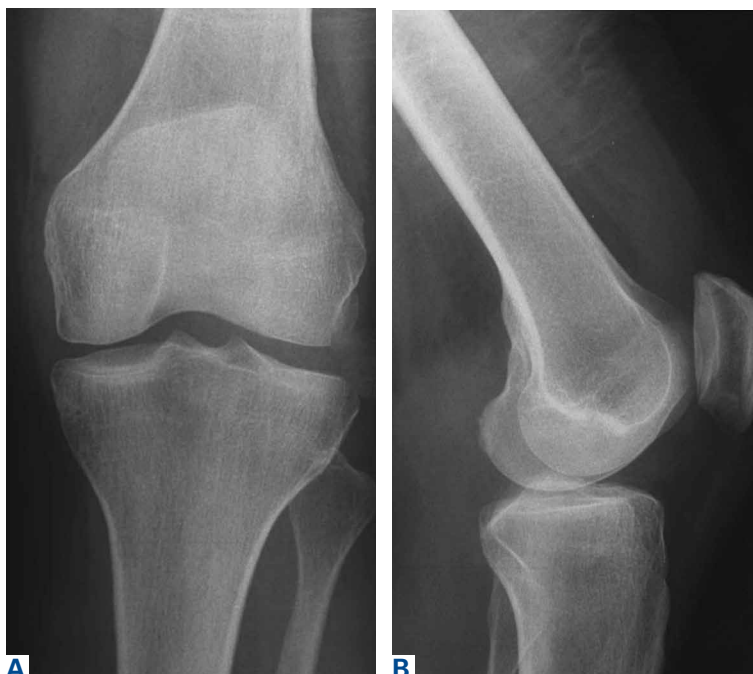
(A) Anteroposterior and (B) lateral radiographs of normal left knee, April 2002.
